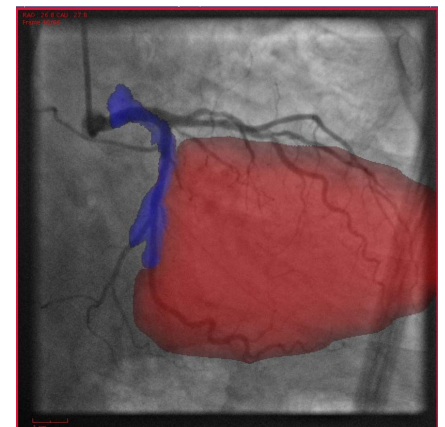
A patient's left ventricle and LCA vessel are shown fused with X-ray angiography.
